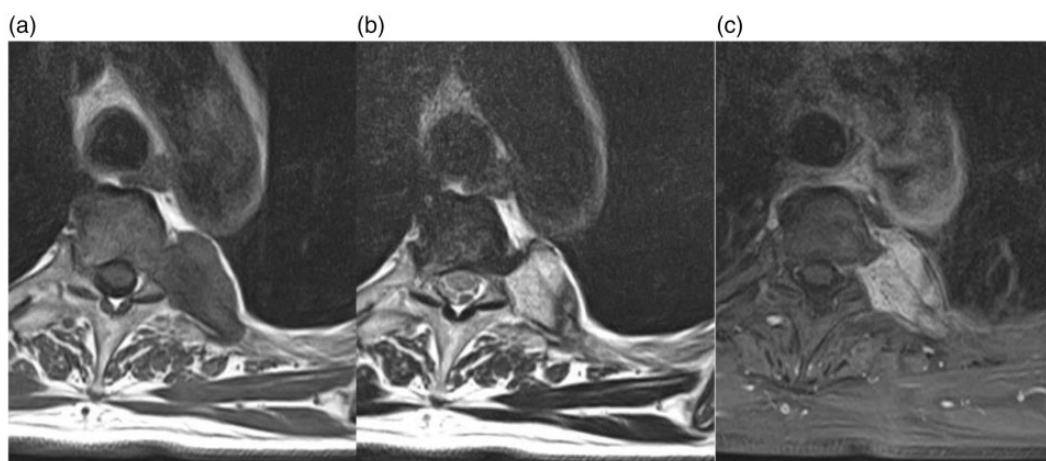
MR images of the affected rib. (a) T1W sequence, (b) T2W sequence, and (c) T1W fat-saturation sequence with gadolinium enhancement.
